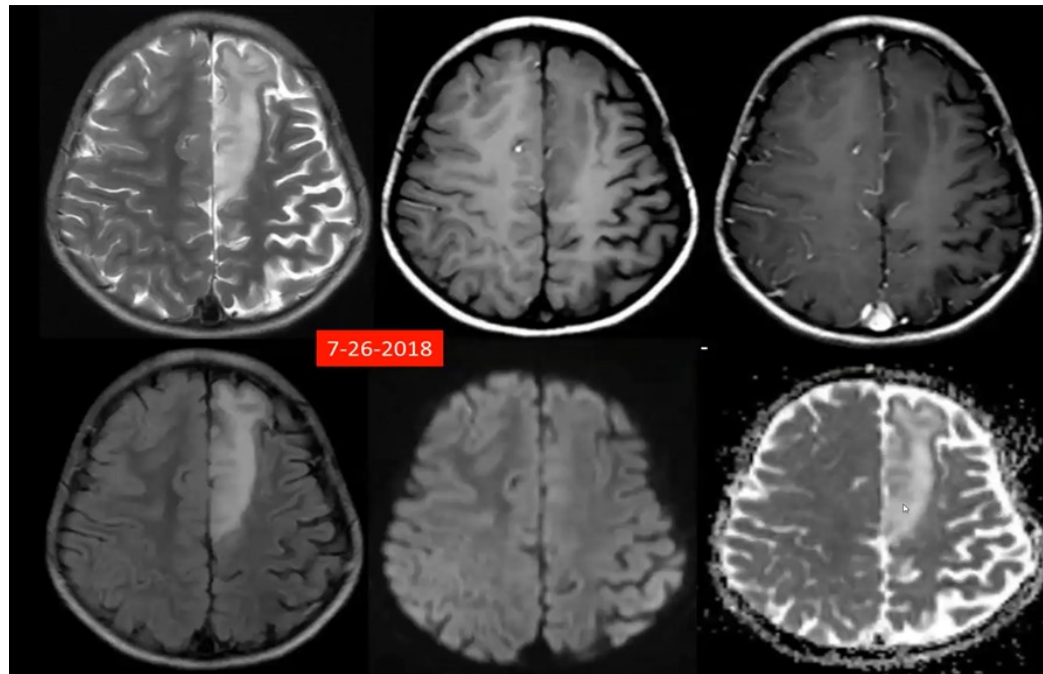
Cranial MRI done in 2018 showing T1 hypointense, T2/FLAIR hyperintense region on the left parasagittal area of the frontal lobe (arrow), with no restricted diffusion or contrast enhancement. Mild left cerebral hemiatrophy is likewise seen.
